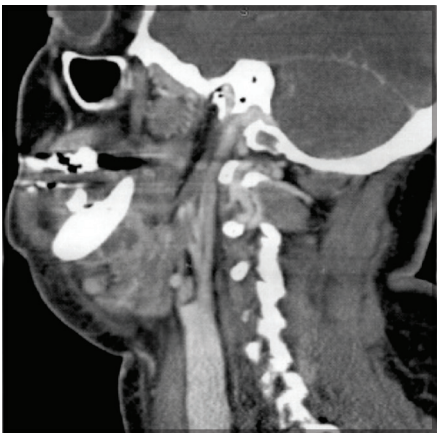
Case 2. Computed tomographic scan showing the sublingual and submandibular hematoma.
